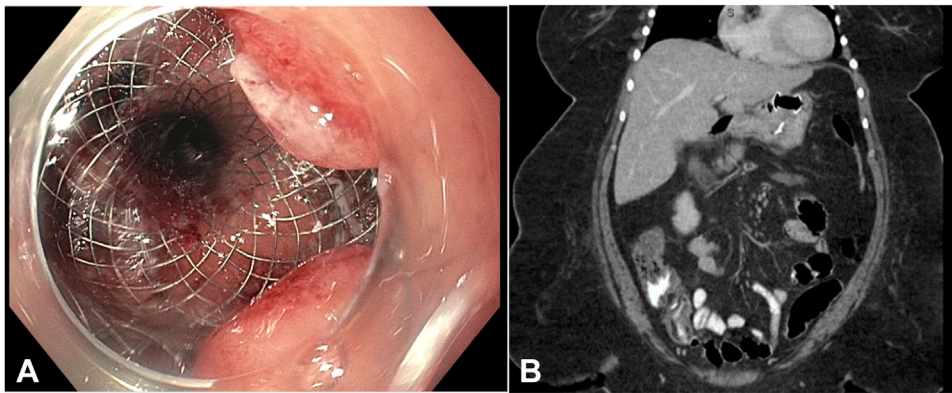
A, Endoscopic view of gastrogastric fistula after lumen-apposing metal stent placement in the gastrogastric fistula. B, CT scan 2 months after lumen-apposing metal stent placement showing no extravasation of contrast into the peritoneum.
